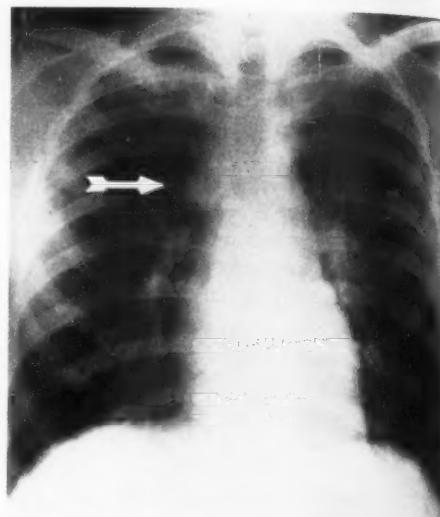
Postero-anterior roentgenogram of the chest, showing an abnormal ovoid density in the right tracheobronchial angle.
